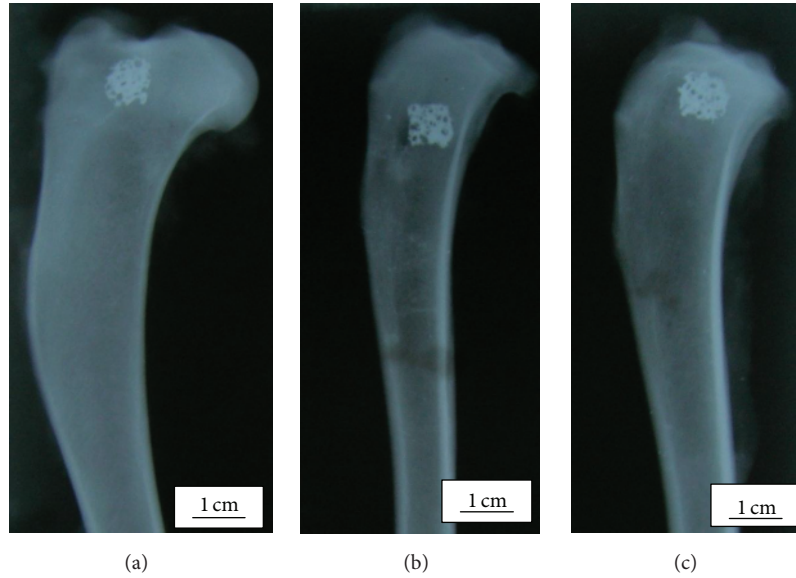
(a, b, c) 2nd, 4th, and 6th month radiography.
